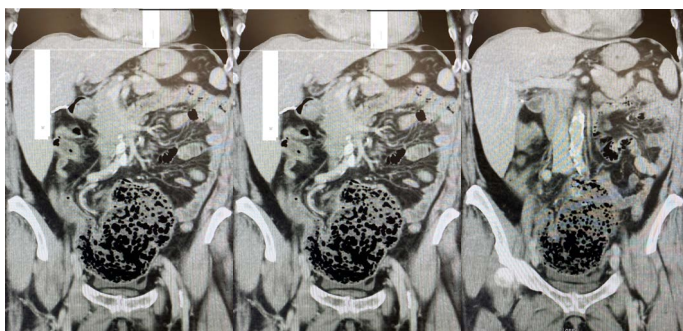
(A). CT of Abdomen and Pelvis with Contrast. Anterior view/Coronal plane. All CT scans at this Facility Use At Least One of These Dose Optimization Techniques: Automated Exposure Control; mA and/or kV Adjustment Per Patient Size (Includes Targeted Exams Where the Dose Is Matched to Clinical Indication); or Iterative Reconstruction. Contrast Material: OMNIPAQUE 350; Contrast Volume: 100 ml; Contrast Route: INTRAVENOUS (IV).
